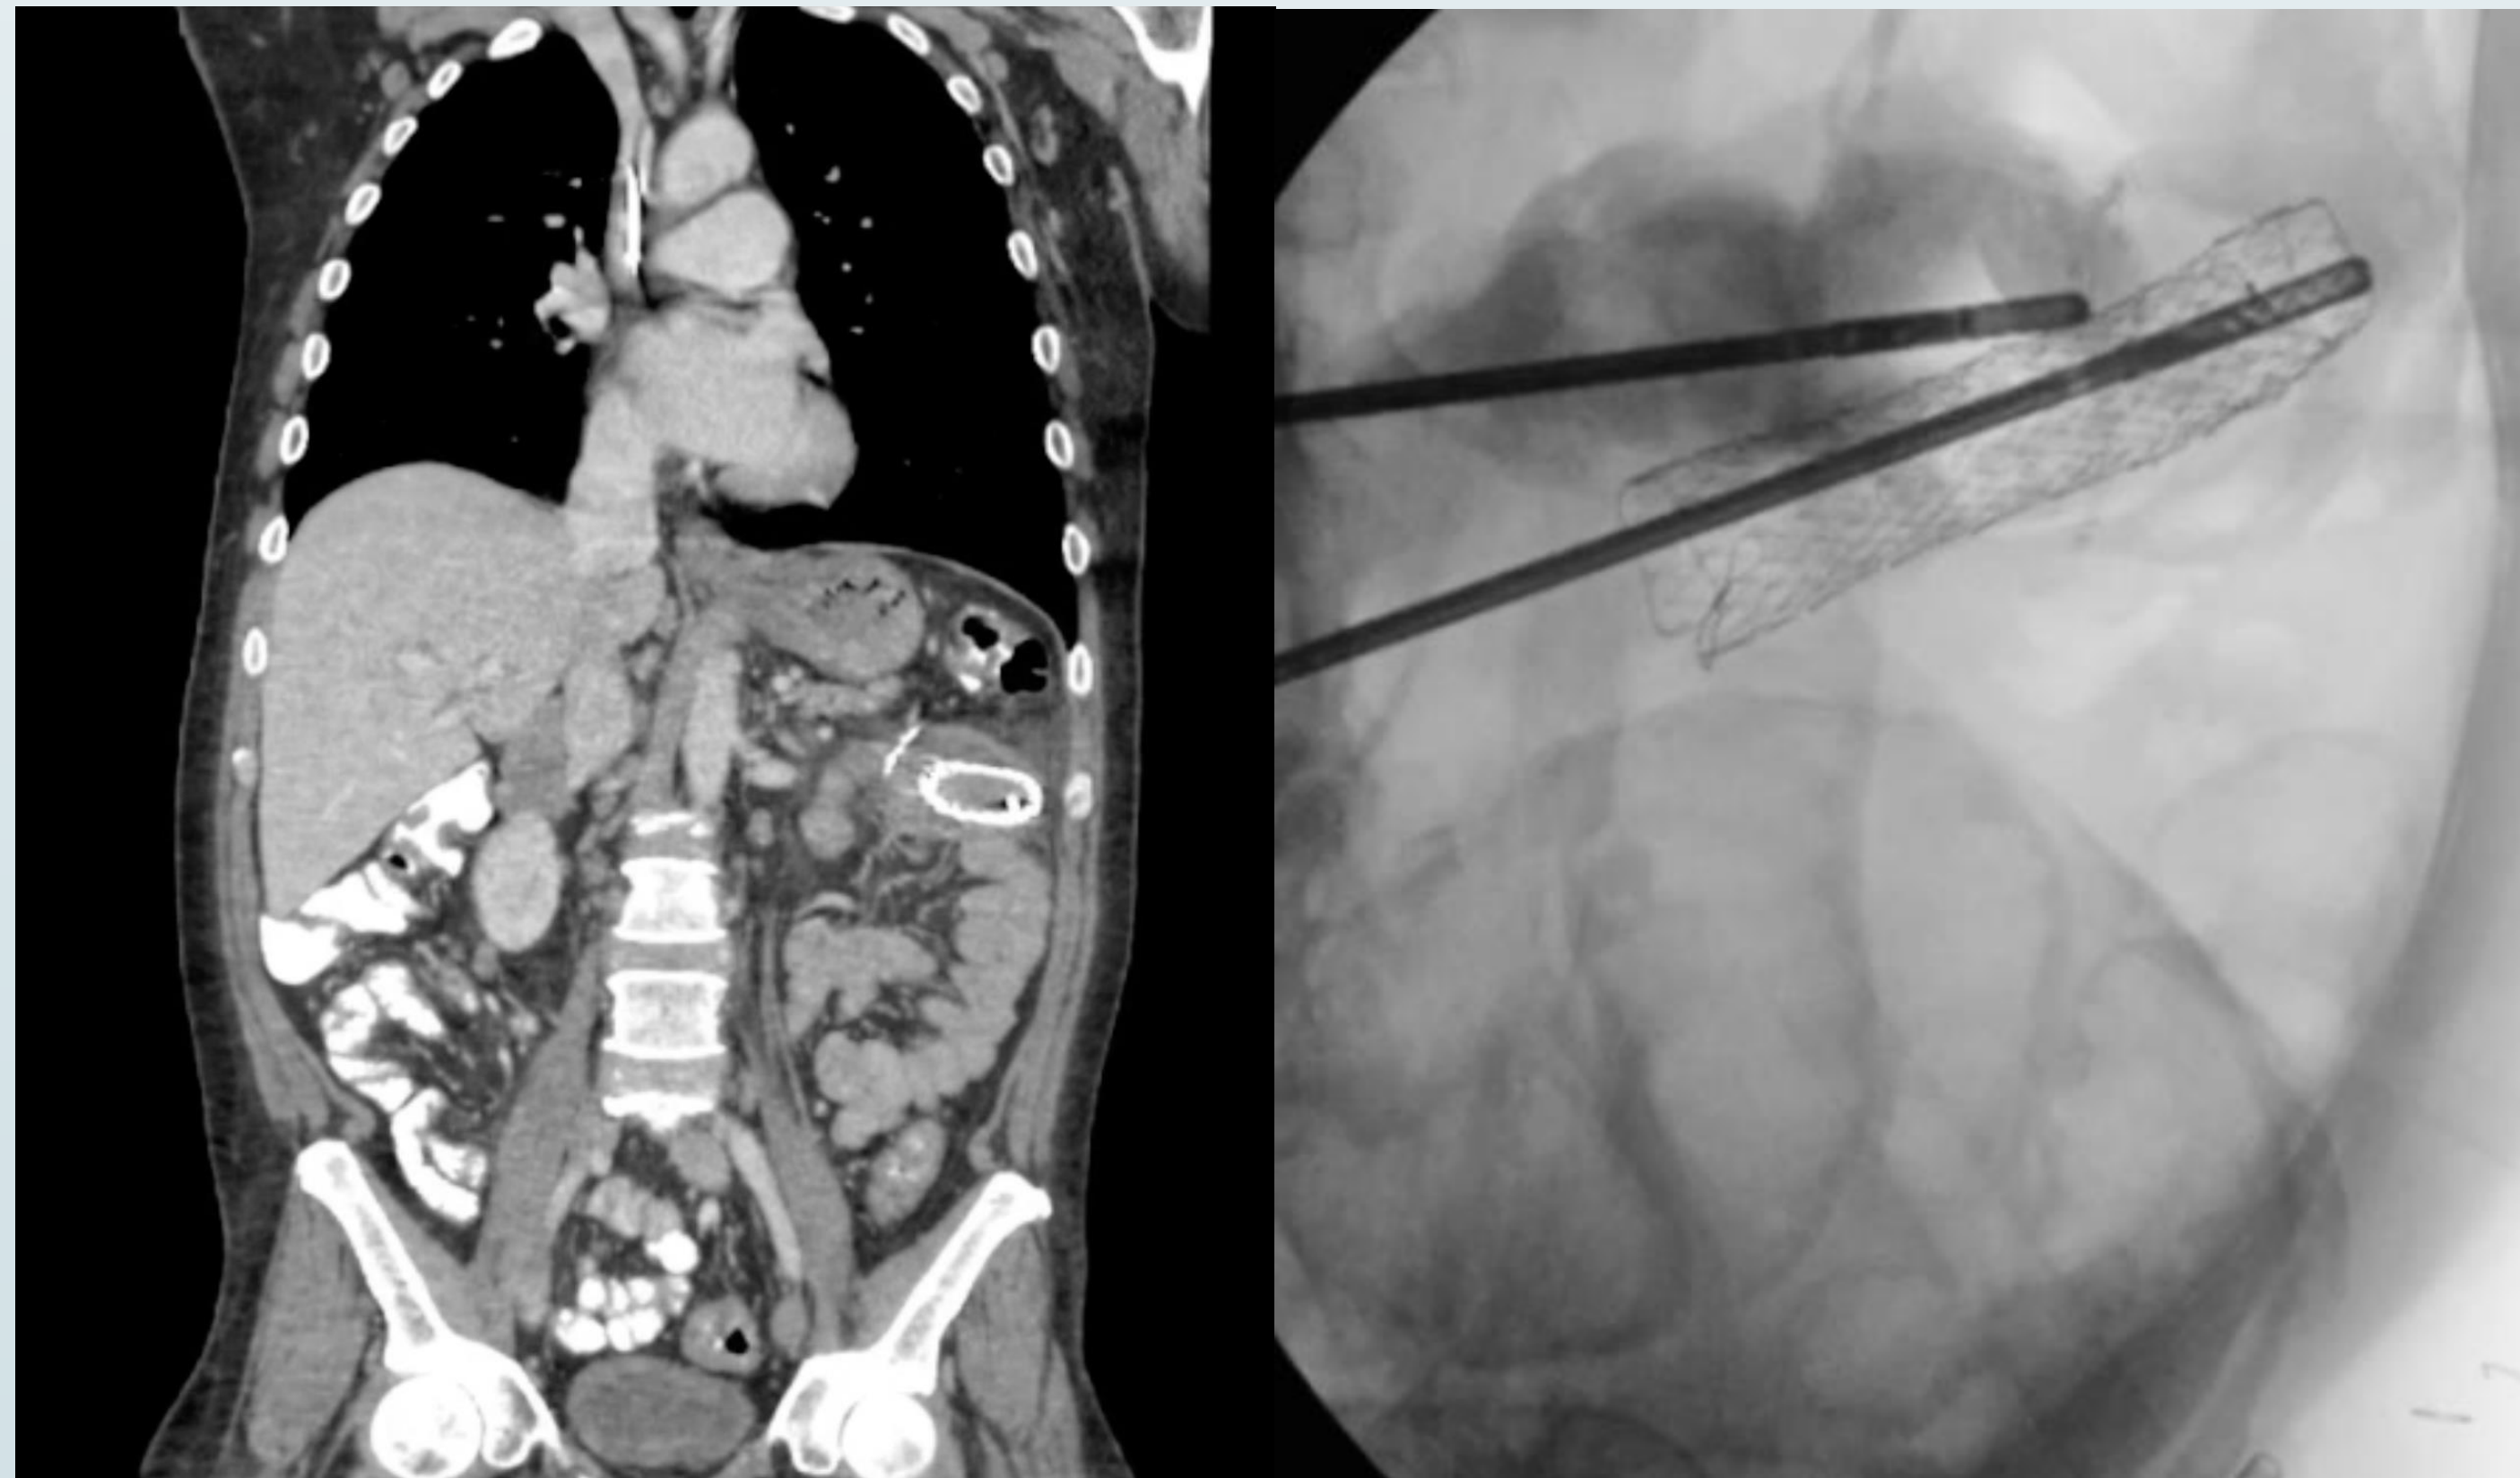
Preoperative CT demonstrating migrated esophageal stent within the proximal small bowel (left). Intraoperative fluoroscopic localization of stent in proximal small bowel (right).
